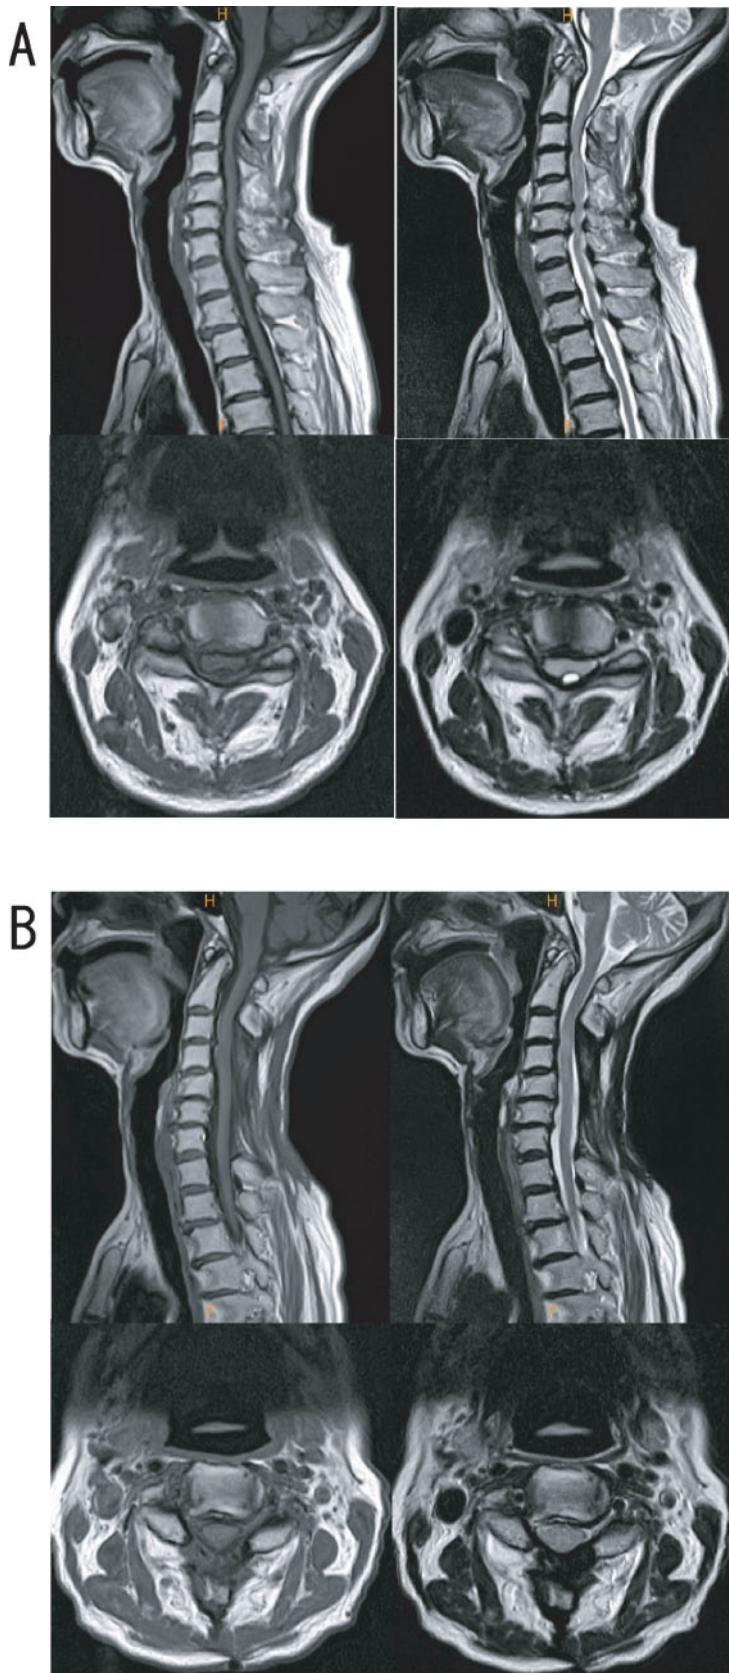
Case 2. (A) Cervical magnetic resonance imaging reveals a cystic lesion at the C2-3 level that is hypointense on T1-weighted images and hyperintense on T2-weighted images. The mass is located in the posterior aspect of the extradural space with compression of the spinal cord. (B) Post-operative magnetic resonance imaging after two years shows complete resection of the cyst and a decompressed spinal cord.
